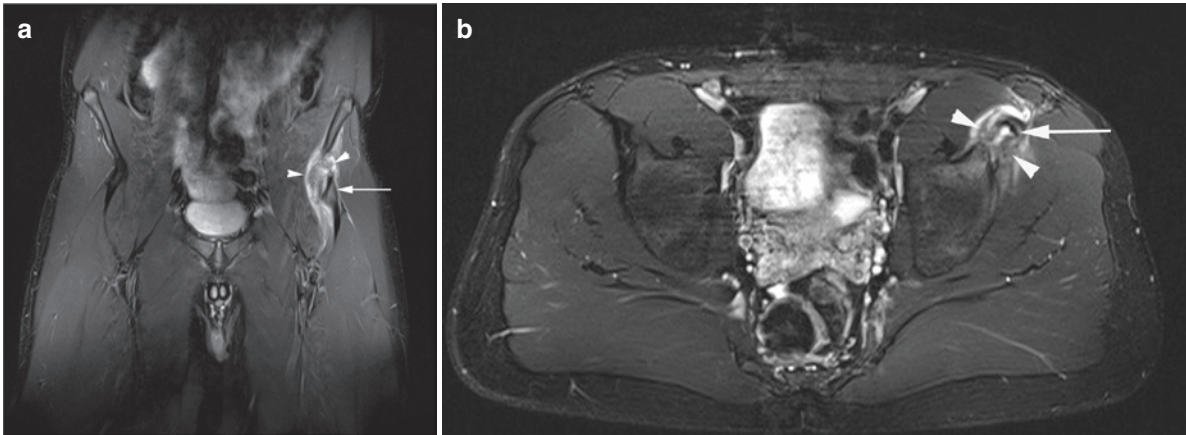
Apophyseal injury. A 16-year-old rugby player with sudden anterior hip pain. (a) Coronal and (b) axial T2FS MR images show avulsion of the left anterior inferior iliac apophysis (arrow), hematoma (arrowheads), and intact indirect head of rectus femoris
